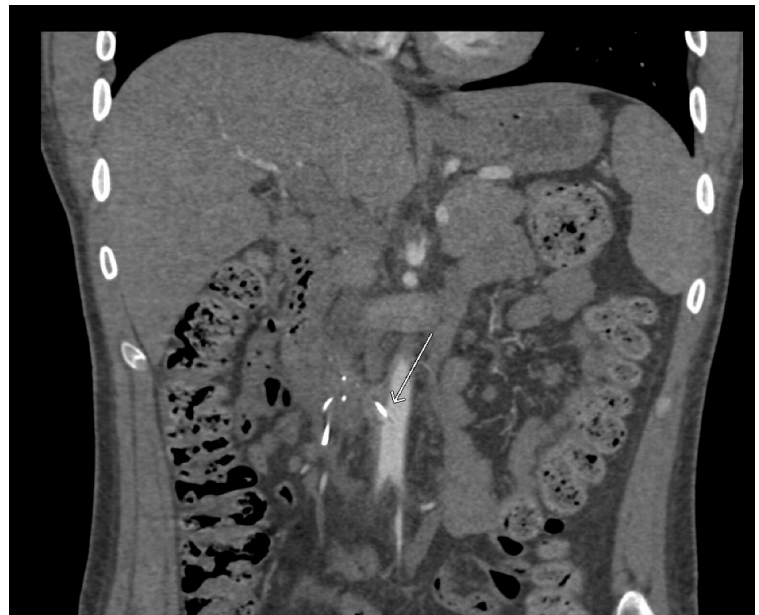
CT angiogram, coronal view, showing a strut penetrating the wall of the aorta.
